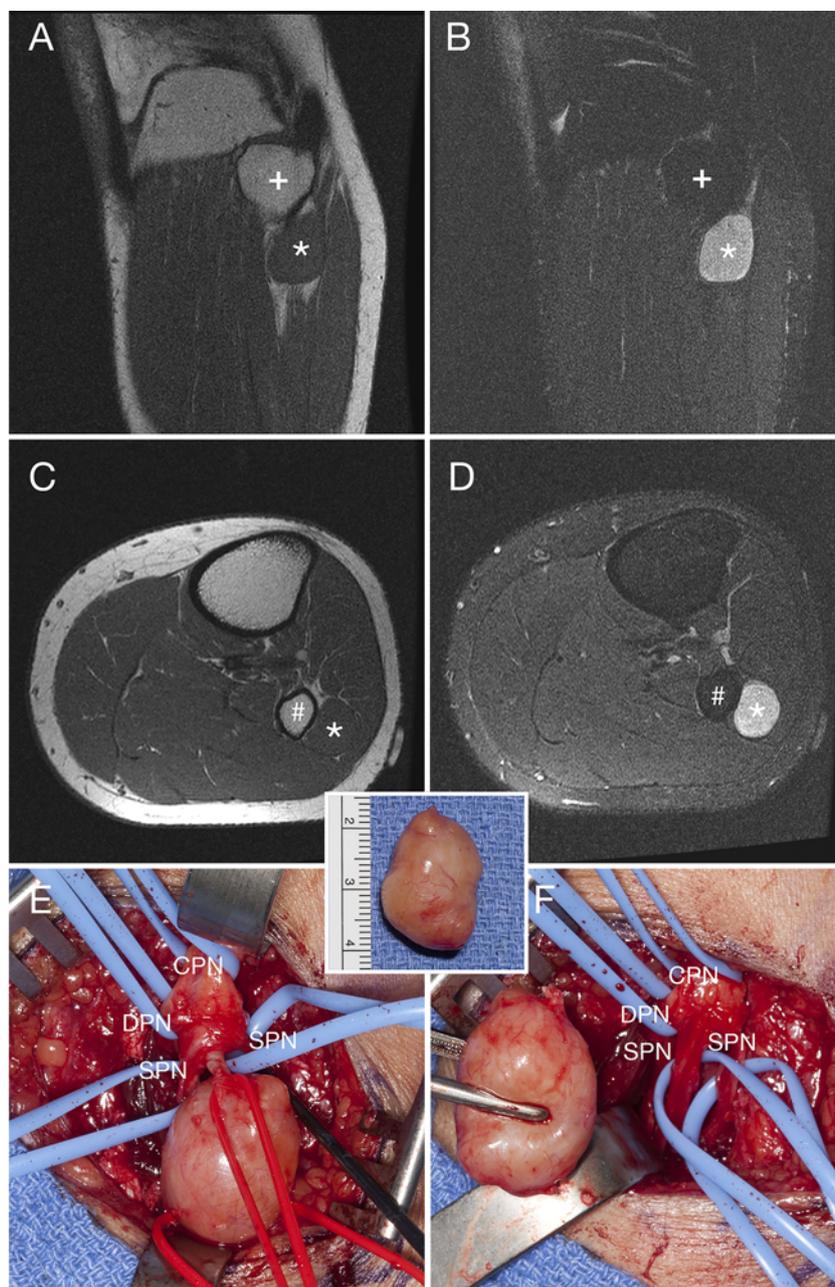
Example of a CPN schwannoma distal to the FH, at the fibular neck. A–D: Preoperative T1-weighted and T2-weighted coronal (A and B) and axial (C and D) MR images. The asterisks indicate the location of the tumor; the plus signs, the FH; and the pound signs, the fibular neck. E and F: Intraoperative images showing the enucleation from the superficial peroneal nerve branch (SPN), just distal to the division of the CPN into the superficial nerve and the deep peroneal nerve (DPN) branches.
